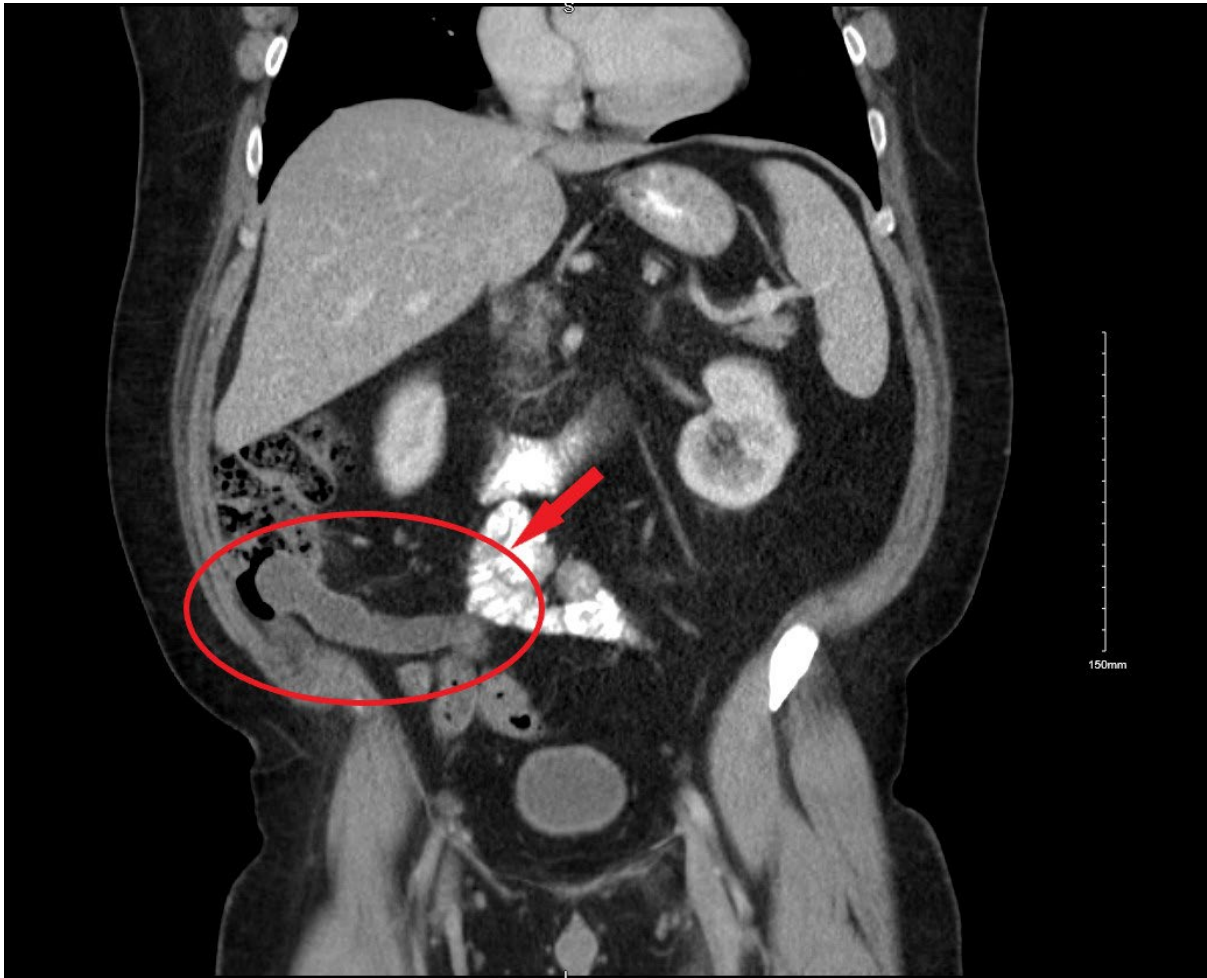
Intravenous and oral contrast-enhanced CT abdomen and pelvis – Coronal image
